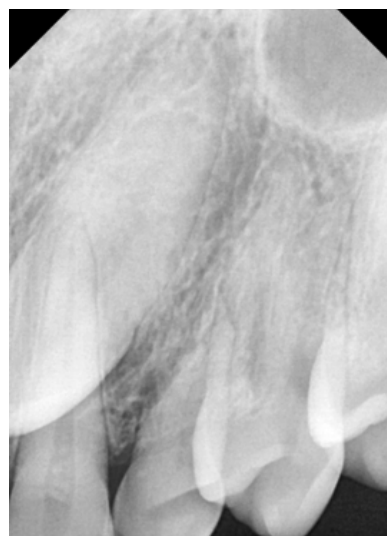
Initial X-ray image.
